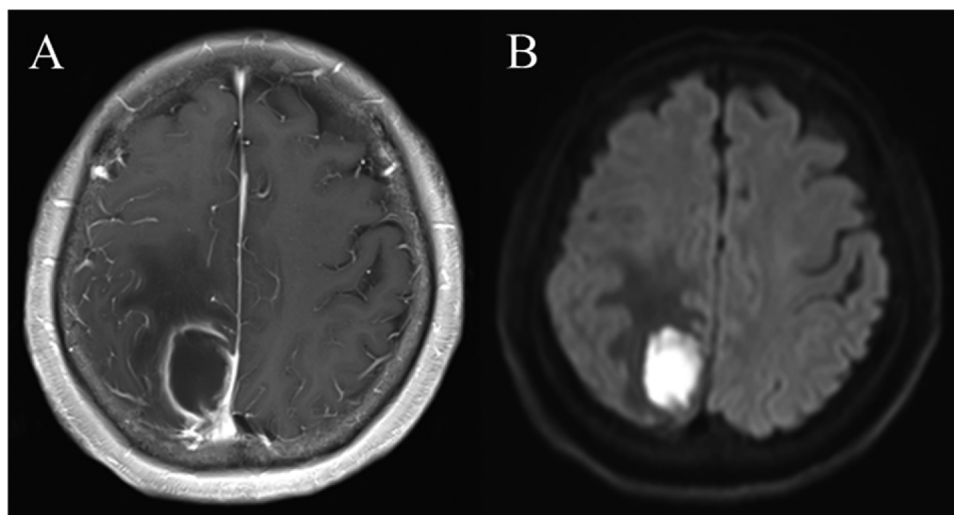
Preoperative axial post-contrast T1-weighted MRI (A) and diffusion weighted axial MRI images showing mass lesion of the right occipital region with diffusion restriction.
